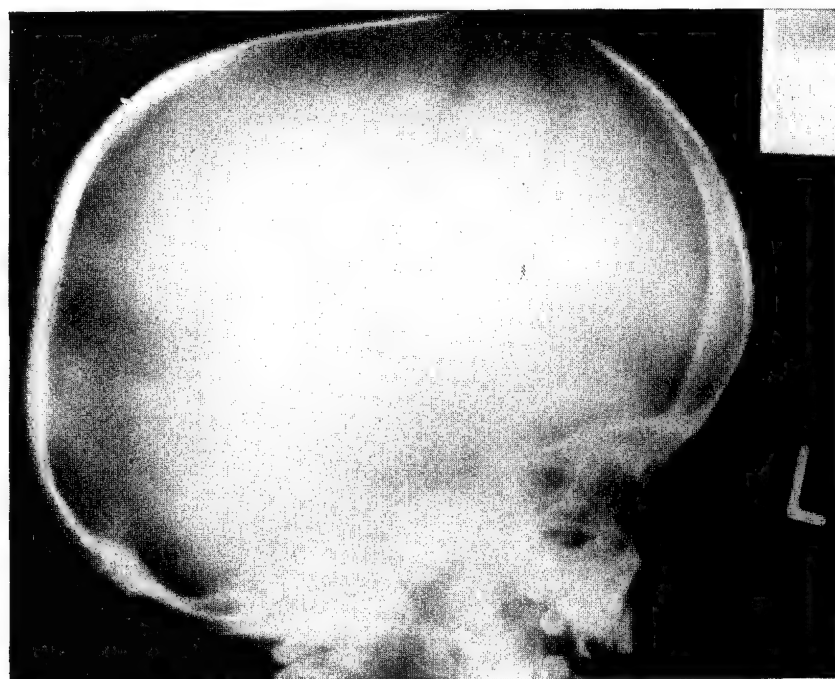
Roentgenogram of skull.
